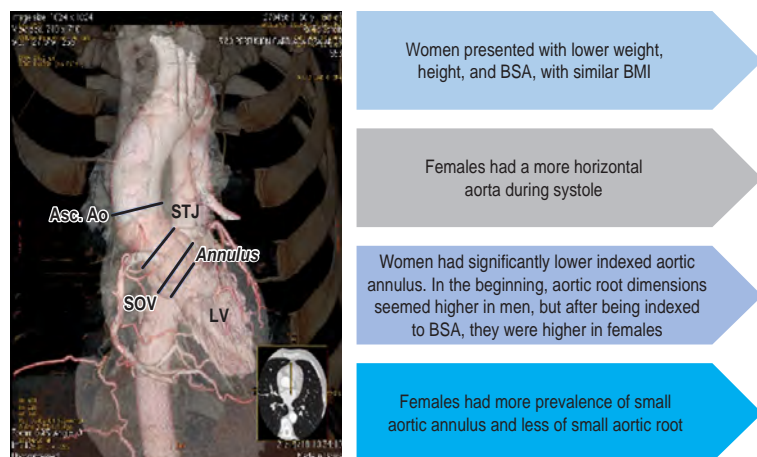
Sex-related differences of the aortic root features in a structural and functional cardiac computed tomography (CCT) analysis.
